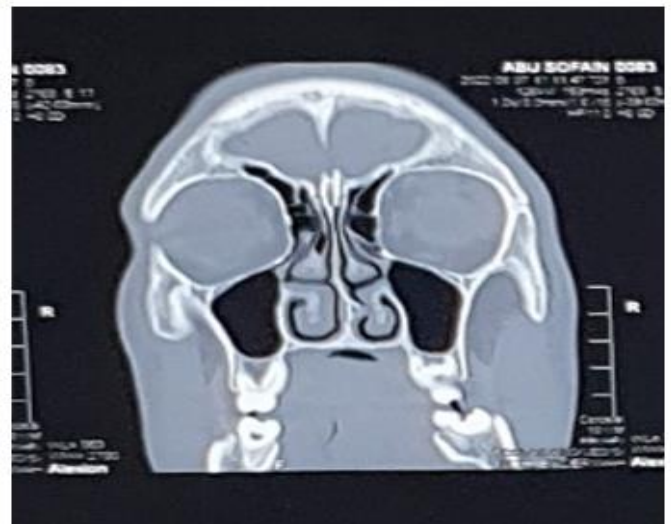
Computed tomography of nose and paranasal sinuses showing left deviated nasal septum
